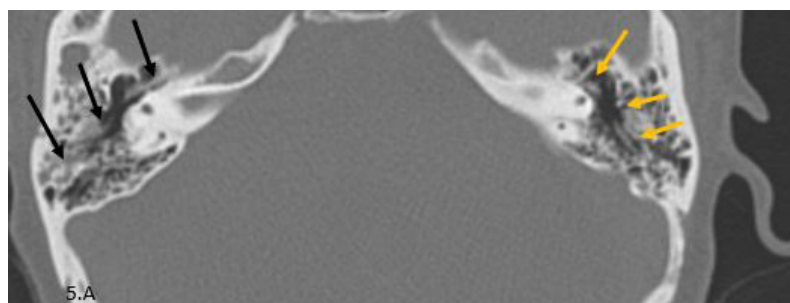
A: Axial CT view, bone window revealed a longitudinal right fracture of the petrous bone with the fracture line demonstrated by the arrows (black arrows), left petrous bone longitudinal fracture (yellow arrows).
